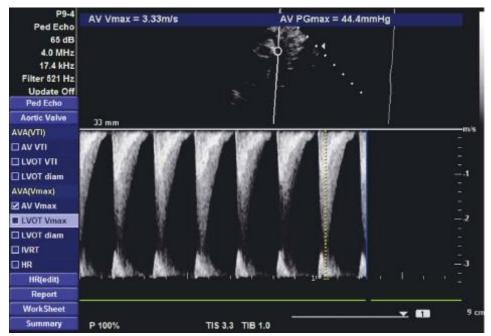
2D Transthoracic echocardiography, suprasternal section. Peak velocity is 3.33 m/sec and the pressure gradient is 44.4 mmHg which constitute as indications for severe impairment of blood flow
